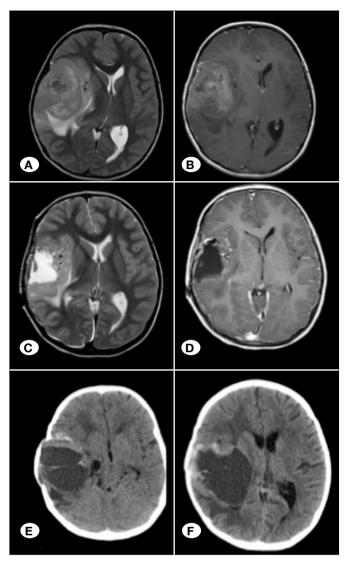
Neuroimaging findings of a 7-year female patient. A huge and heterogeneous mass is seen in the right temporal lobe and insula with compression of the right deep gray matter and lateral ventricle, and subfalcine herniation to the left (A, B). A month after the operation, the resection cavity with adjacent thickening and T2 hyperintensity suggesting edema and/or nonenhancing tumor (C, D). An enhanced cranial CT, obtained 6 months later shows a recurrent cystic, heterogeneous mass with peripheral solid enhancing portions, again with mass effects (E, F).
